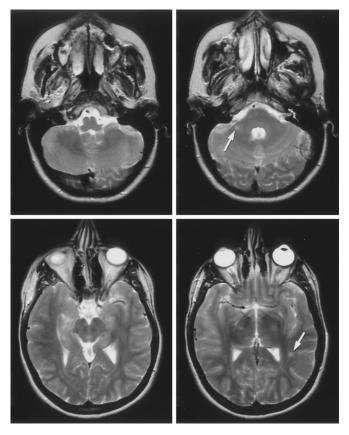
Axial T2-weighted MRI obtained at the time of initial presentation with optic neuritis. Arrows indicate areas of white matter hyperintensity consistent with demyelination.
